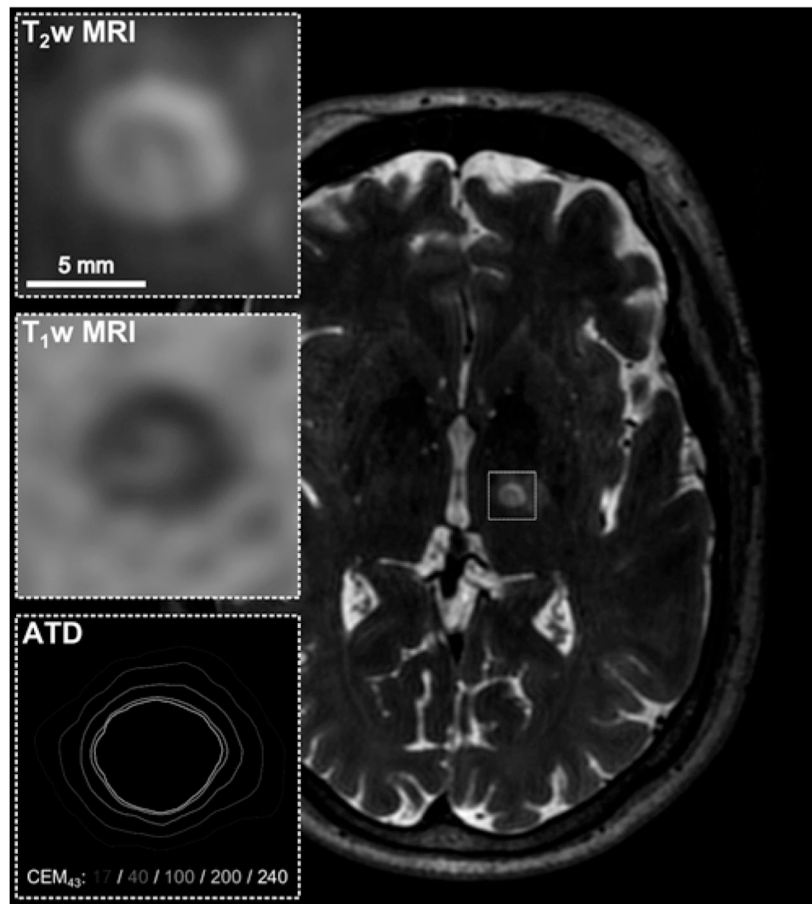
Axial T2w MR images acquired 1 day posttreatment showing a unilateral thalamotomy in the VIM nucleus (*dashed square*). Insets: Magnified views of the same patient's T2w MRI, T1w MRI, and ATD profiles, respectively (17, 40, 100, 200, and 240 CEM_{43}) (FOV = 12×12 mm). In this patient, six sonications with focal temperatures between 50°C and 54°C (duration range = 15–45 seconds) were applied to generate a lesion.
